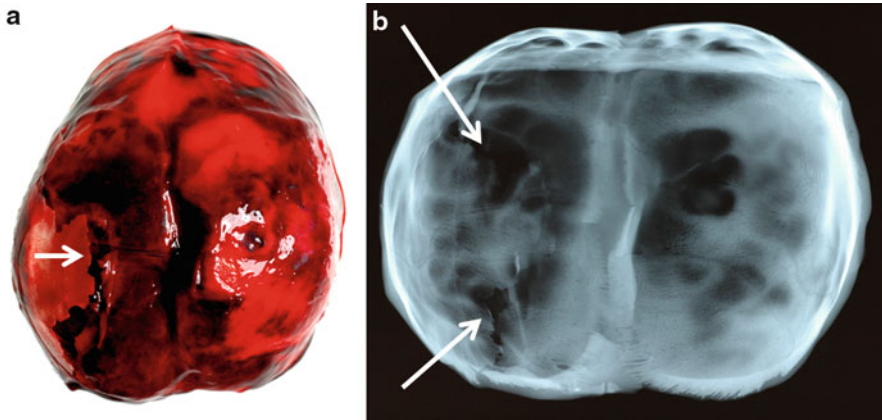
Skull fractures through craniolacunae following vacuum extraction. Skull, gross (a) and postmortem radiograph (b) demonstrating craniolacunae and skull fractures. A term infant delivered by vacuum-assisted vaginal delivery developed hypoxic-ischemic encephalopathy and died on the second day of life. The craniolacunae are defects in the skull and are seen as oval lucencies on radiographs (Image courtesy of Joseph Siebert, Ph.D.)
